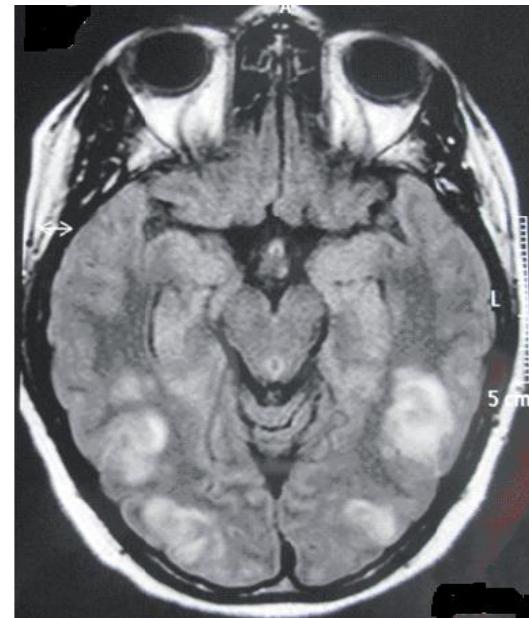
Encephalic MRI: Presence of multiple patches of increased signal in weighted sequences in T2 mainly in the parietal, temporal and occipital lobes bilaterally, with cortical-subcortical localization, by parenchymal edema.
